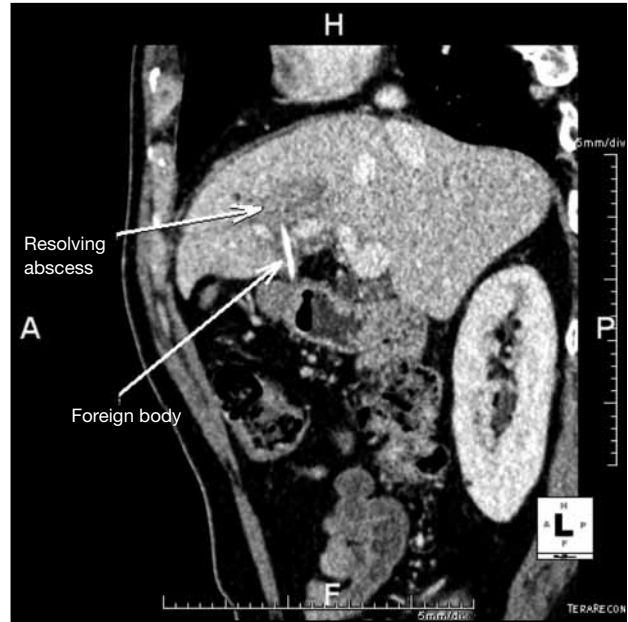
Follow-up computed tomography at 6-week interval shows reduction in size of the abscess. The foreign body remains static in size and location.
